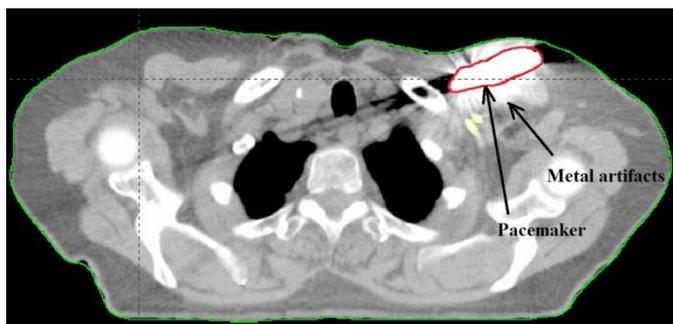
CT image with artifacts and cardiac device (pacemaker)
